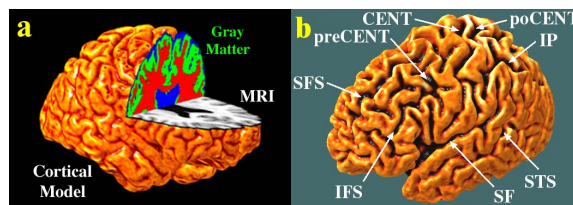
Cortical surface models are extracted from MRI scans (a). On individual models, 3D parametric curves are manually traced to represent 72 sulcal landmarks (some shown in (b), defined in [7]), which in turn constrain the elastic deformation for cortical pattern matching.
